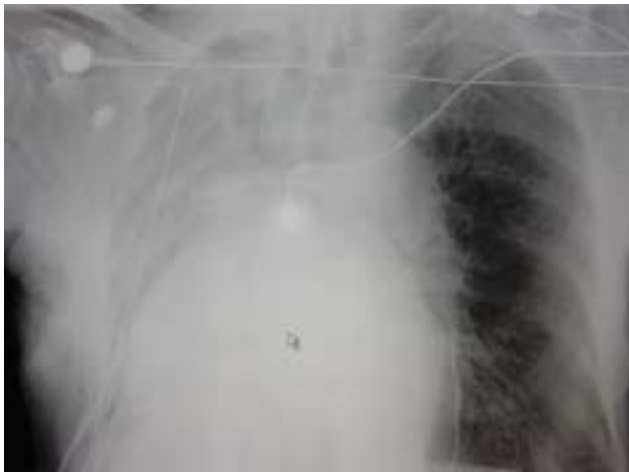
Portable chest x-ray reveals well-placed thoracostomy tube and endotracheal tubes. However, the right lung appears atelectatic and has shifted the mediastinum to the right.
